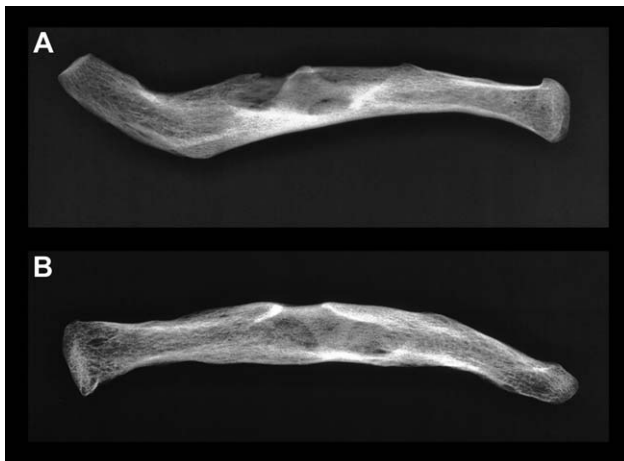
Supero-inferior (A) and antero-posterior (B) radiographic images of clavicle SGS01 revealing the lack of zones of bony activity and reactive changes around the foramina.
